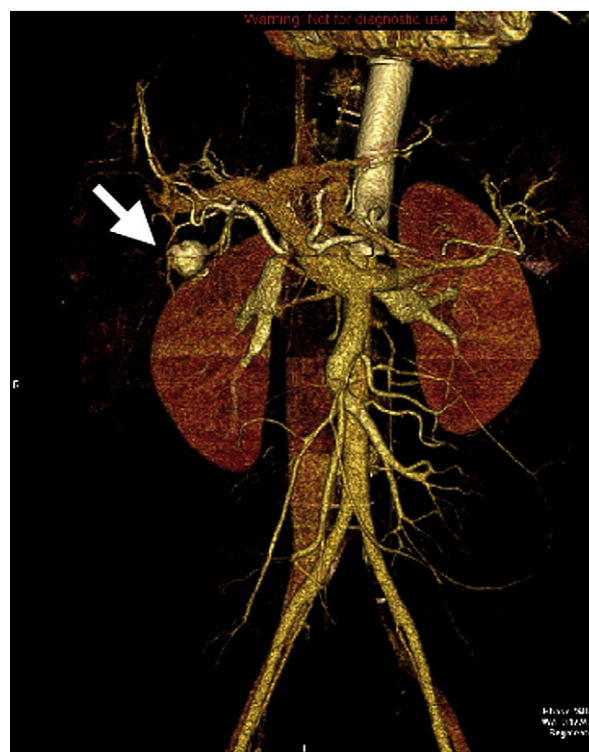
Computed tomography demonstrating right hepatic artery pseudoaneurysm with hepatic capsular rupture (arrow) and extravasation into the peritoneal cavity.
